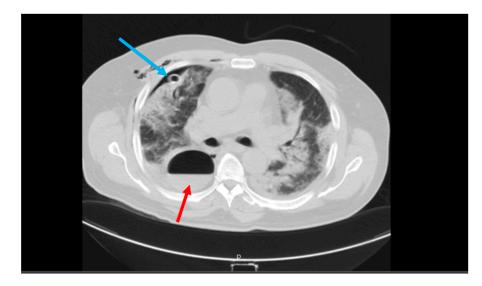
An unsuccessful drainage of a lung abscess (red arrow) using a CT scan guide, resulting in a pneumothorax in the right lung and a chest tube insertion after that (blue arrow).
